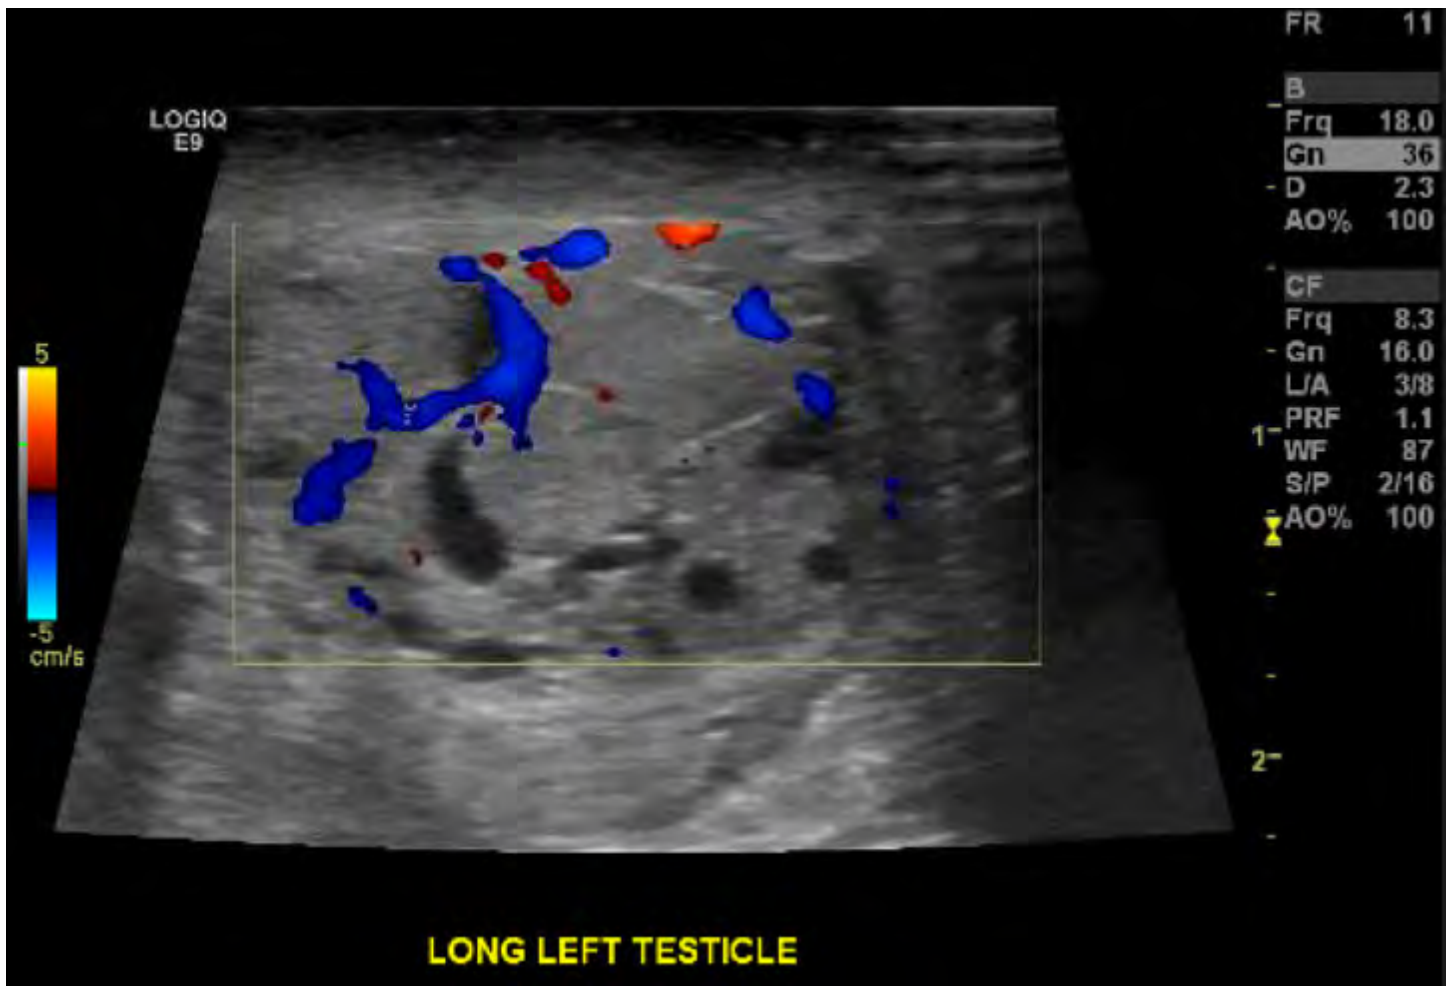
Doppler ultrasound of the left testicle showing internal vascularity.
